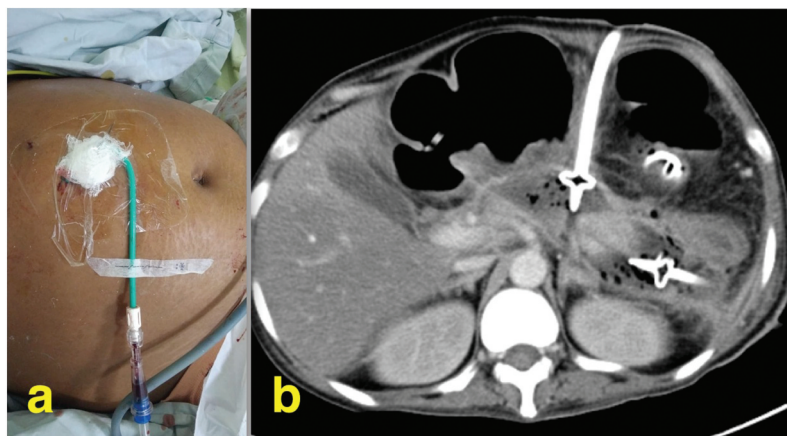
Percutaneous catheter drainage: a) clinical image depicting percutaneous catheter drain in a patient; b) computed tomography imaging post-drainage.
